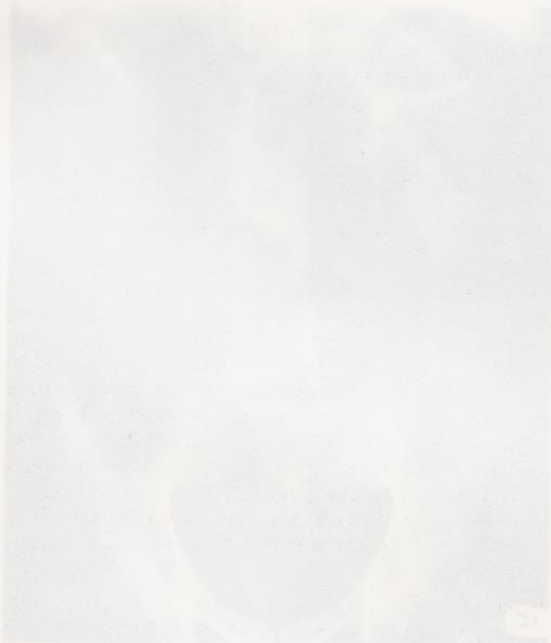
Plain abdominal radiograph showing a small bowel obstruction. This is the same as the patient in the text.
